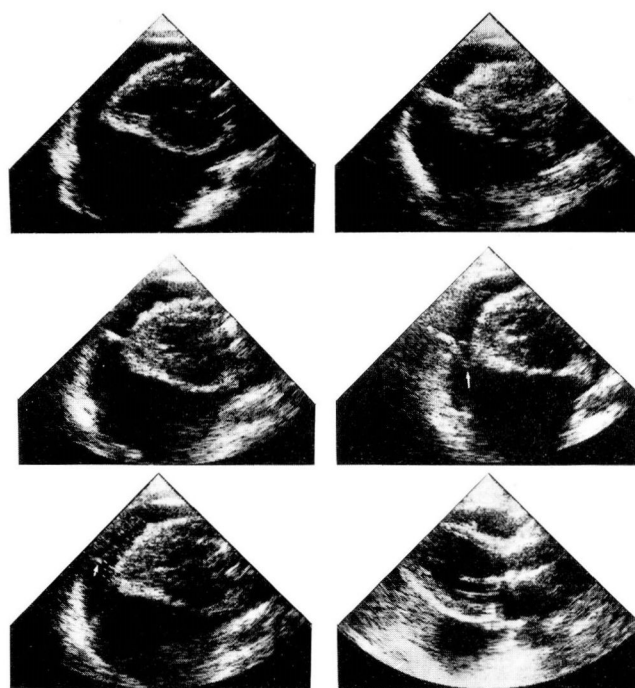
Parasternal long-axis two-dimensional echocardiographic images show a large pericardial effusion with the pericardiocentesis needle inserted (center left), injection of contrast material to verify location (arrow, lower left), guide wire advanced into the pericardial space (upper right), and drainage catheter placement (arrow, center right) to drain the fluid nearly totally.
